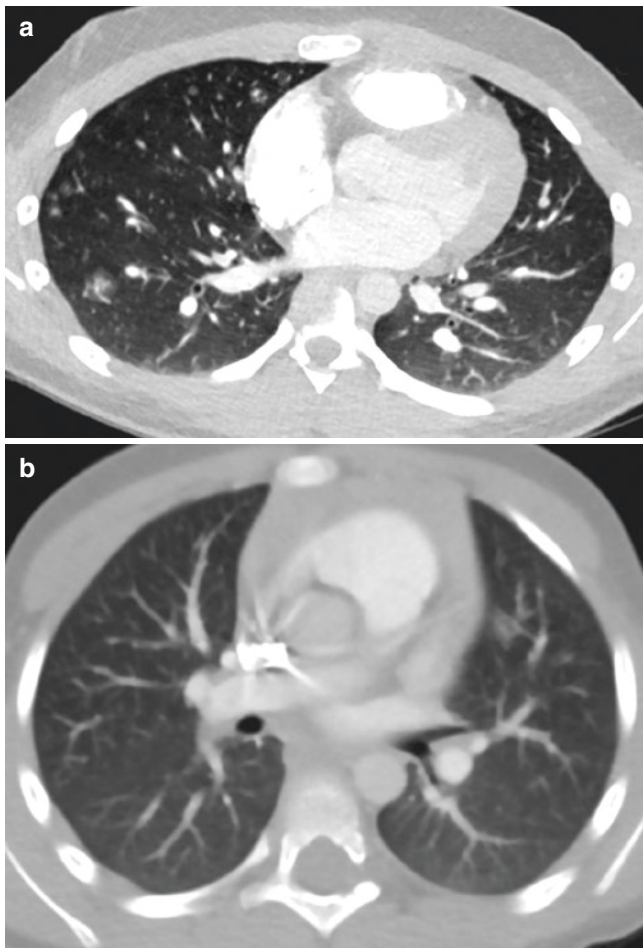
(a) A teenage boy with a history of recurrent mild epistaxis presented with hemoptysis. Chest CT imaging reveals numerous nodular ground-glass opacities suggestive of small arteriovenous malformations. A feeding vessel is visualized with the posterior laterally located AV malformation. He was later found to have a de novo genetic mutation resulting in HHT. (b) A young child with a family history of HHT had screening chest CT imaging. This view shows an early AVM developing in the lingula
